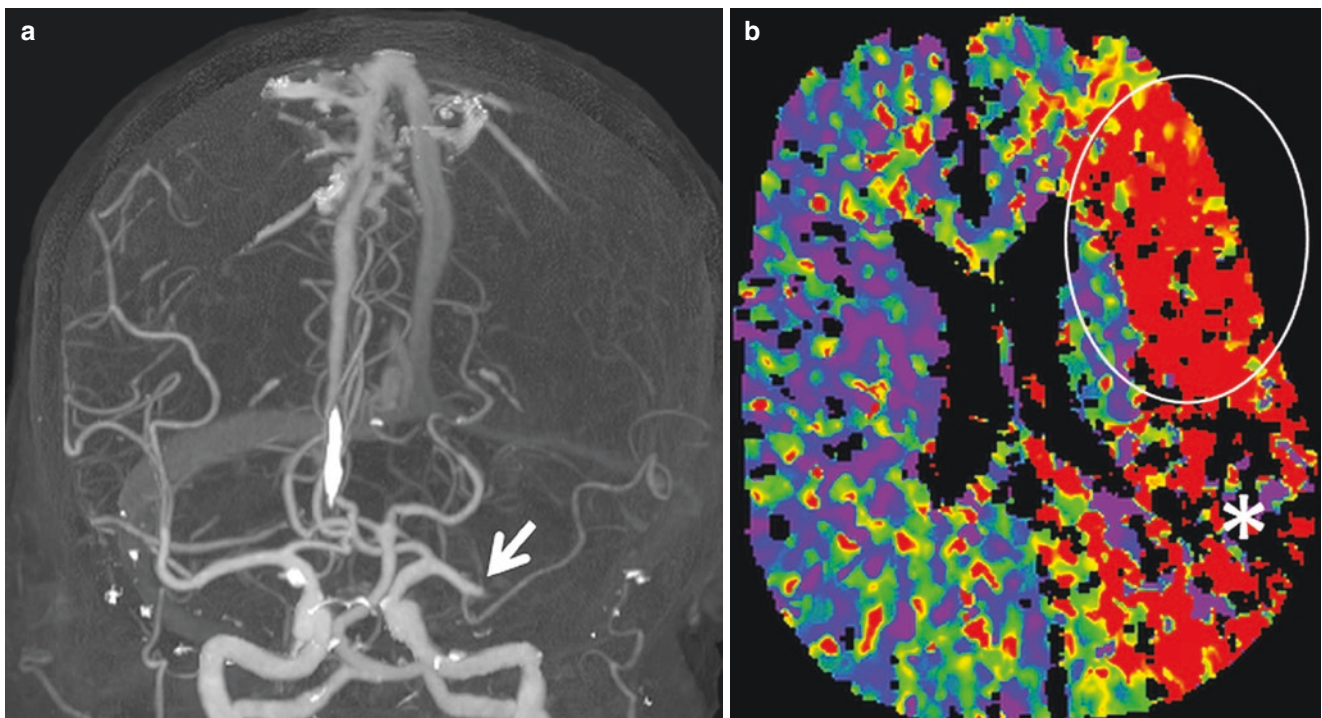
Pattern of large core infarction. Patient with sudden-onset right-sided weakness. NCCT is unremarkable (not shown). (a), 3D CTA MIP image demonstrates acute occlusion of proximal left MCA just distal to the origin of anterior temporal artery (*arrow*). Note there is no reconstitution of distal MCA branches reflecting poor leptomeningeal collaterals. Perfusion images demonstrate marked prolongation of TTD (b), decreased CBF (c), and CBV (d) in the parietal/temporal
